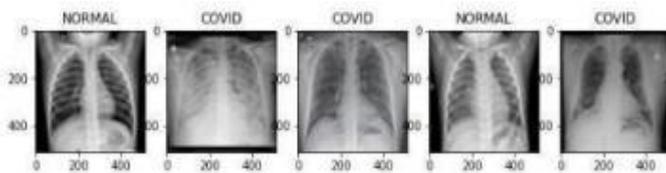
c. Chest X-ray images after loading the image data
